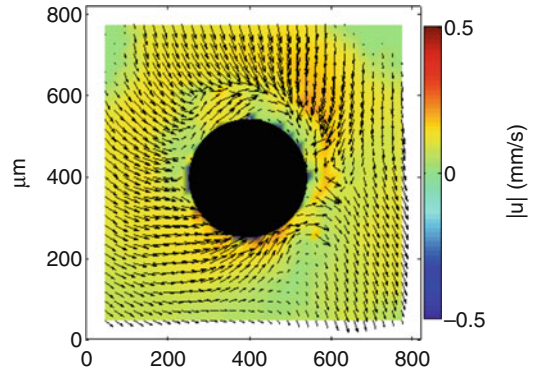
Acoustic microstreaming around an air bubble as recorded with PIV using ultrasound at 28 kHz and 7 kPa
